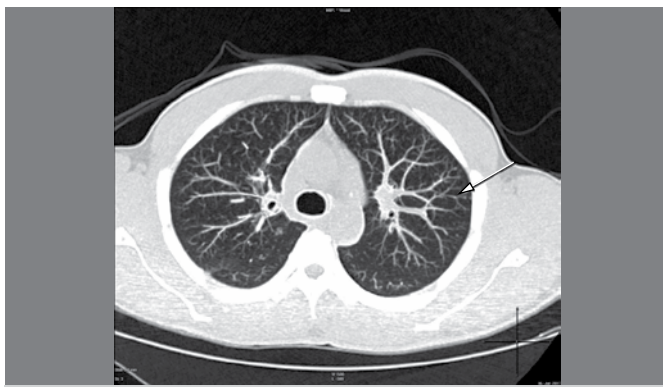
CT scan of the chest showing centrilobular micronodules (arrows).
